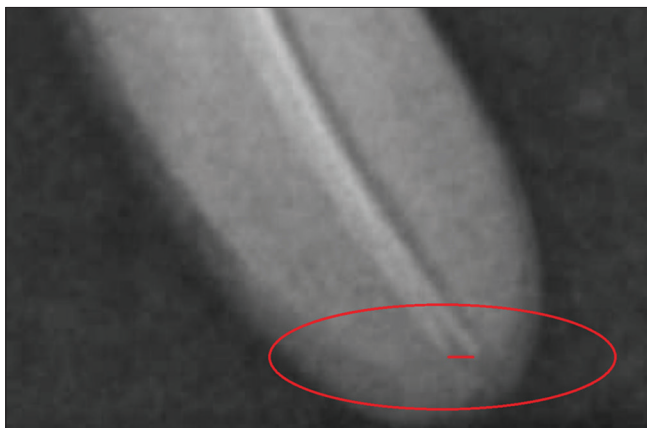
Superimposed pre- and postinstrumentation radiograph with #15 Kfile and master nickel-titanium file
